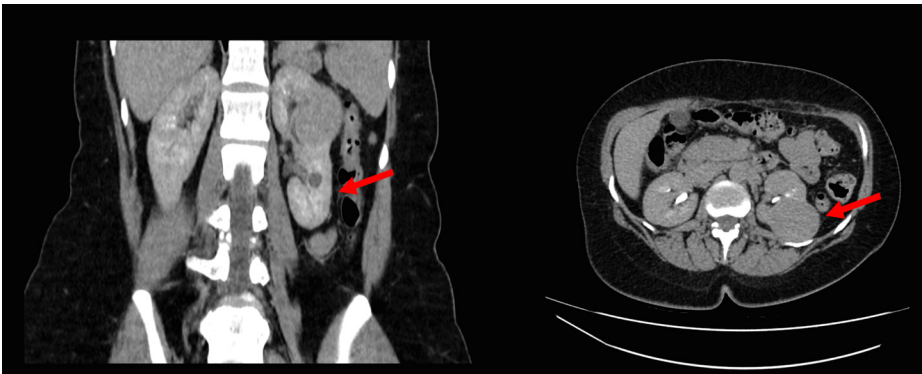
Coronal and transverse planes of solid renal lesions on CT abdomen.
